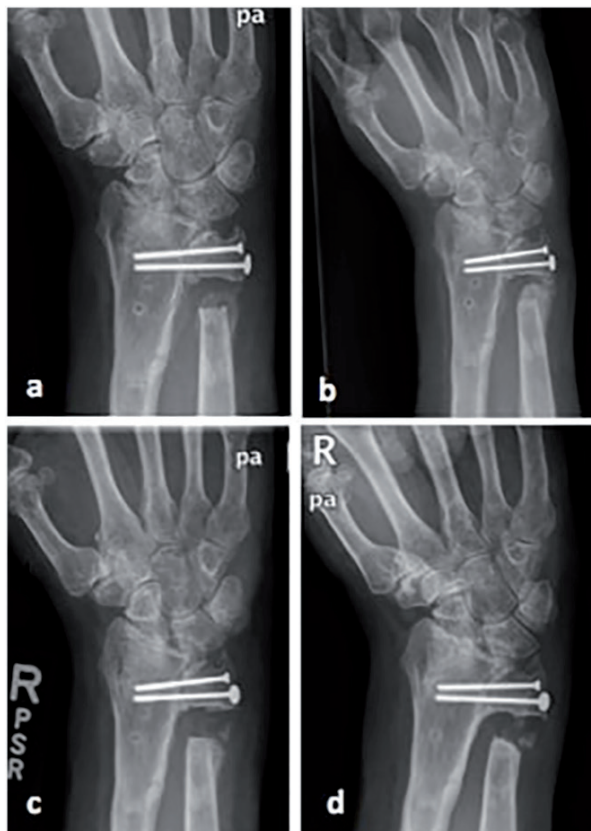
Radiographs of a patient who underwent excision of heterotopic ossification as a reoperation after a Sauvé-Kapandji procedure.
